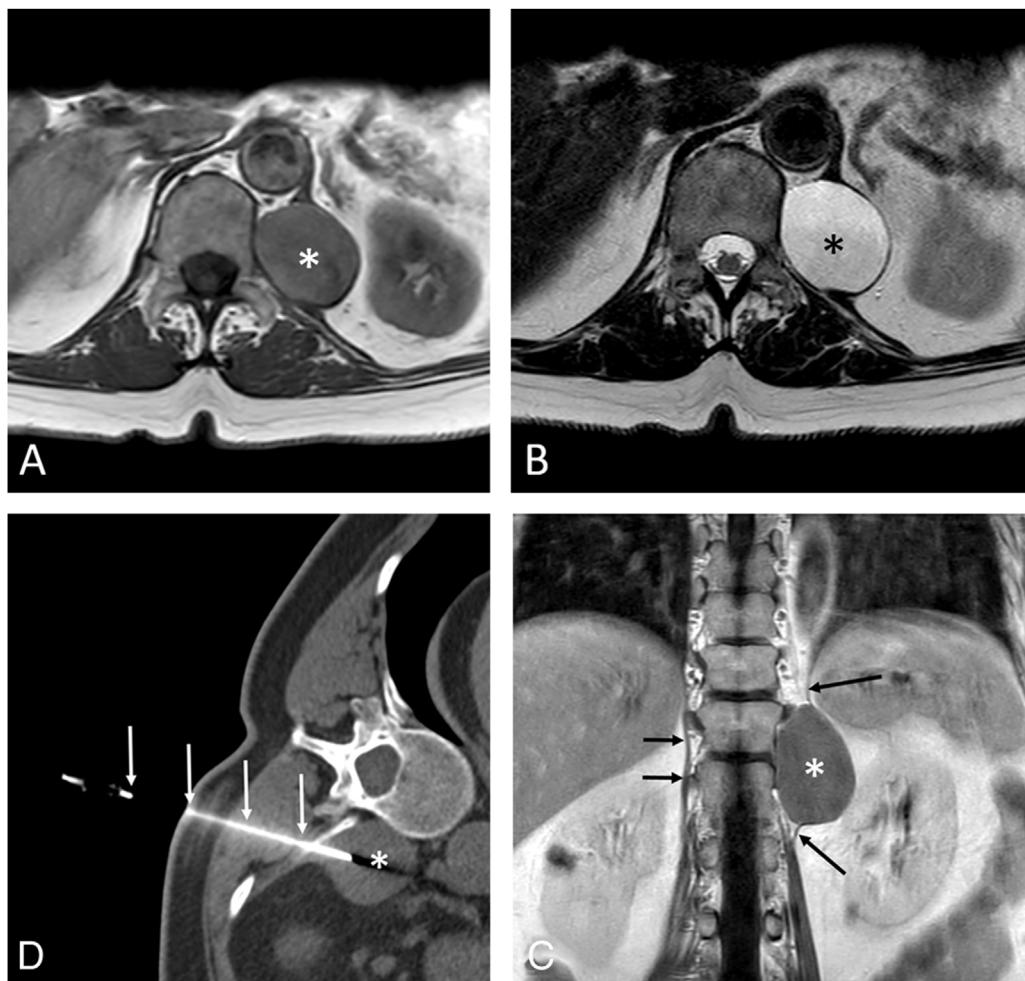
(A and B) Axial T1-weighted (A) and T2-weighted (B) MR images show a well-defined retroperitoneal lesion (asterisk) involving the left crus of the diaphragm. (C) Coronal T1-weighted MR image following the administration of iv contrast confirms the cystic nature of the mass (lack of enhancement) and better shows the relationship of the lesion with the crus of the left hemidiaphragm (long arrows); note the normal appearance of the right crus of the diaphragm (short arrows). (D) Axial CT image (mediastinal window) shows the fine-needle aspiration procedure (arrows) of the lesion (asterisk).
